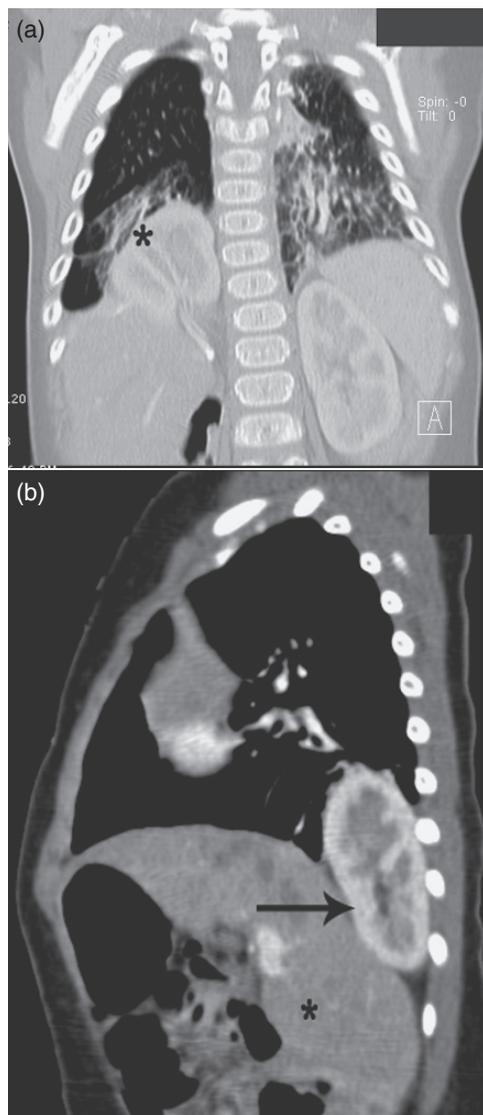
(A) Coronal CT reconstruction right CDH recurrence. Arrow marks reherniated kidney on right. (B) Lateral CT reconstruction right CDH recurrence. Arrow marks kidney in thorax and asterisk marks liver.
